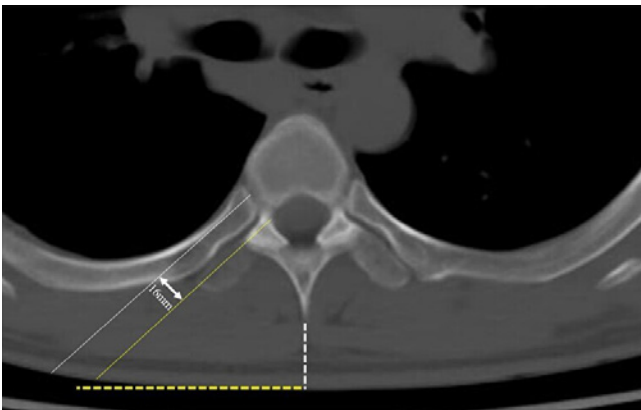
In plain computed tomography (CT) of the thoracic spine, no ossification or calcification lesions are seen. An entry point for the microendoscopy was pre-drawn on CT. Two parallel lines (white and yellow solid lines) show the diameter of the microendoscopic cylindrical retractor, 16 mm wide; the white solid line was drawn along the cortical bone on the thoracic cavity side of the rib, at approximately 50 degrees inward to the perpendicular line. The distance (length of yellow dashed line) from the midline (white dashed line) to the location of the microendoscopic cylindrical retractor was measured.
